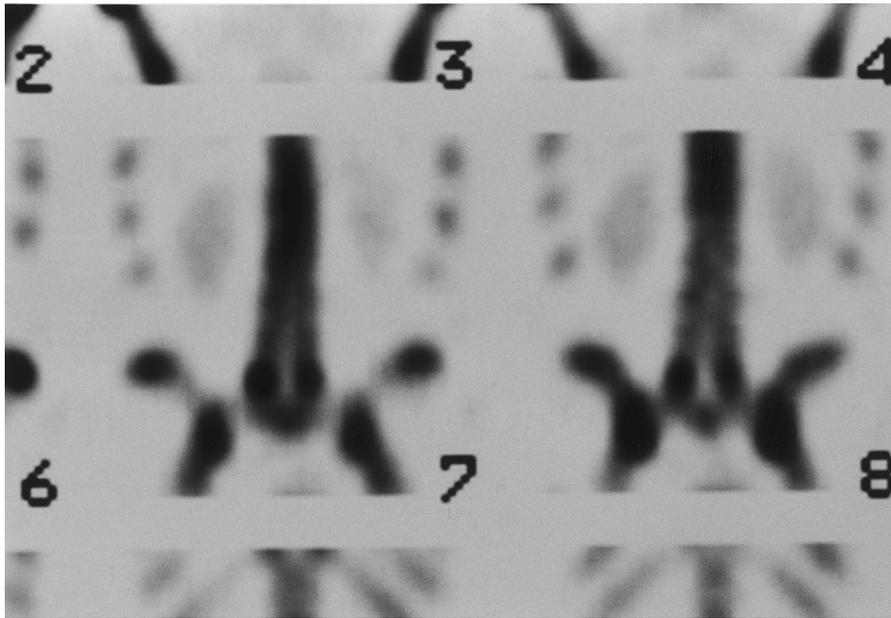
Single-photon emission computed tomography (SPECT) scan. There is intense bilateral uptake of the radionuclide at the L5 pars interarticularis. *Comment:* The positive uptake at the L5 pars indicates the “active” nature of these lesions. This athlete’s back pain was caused by these pars defects.
